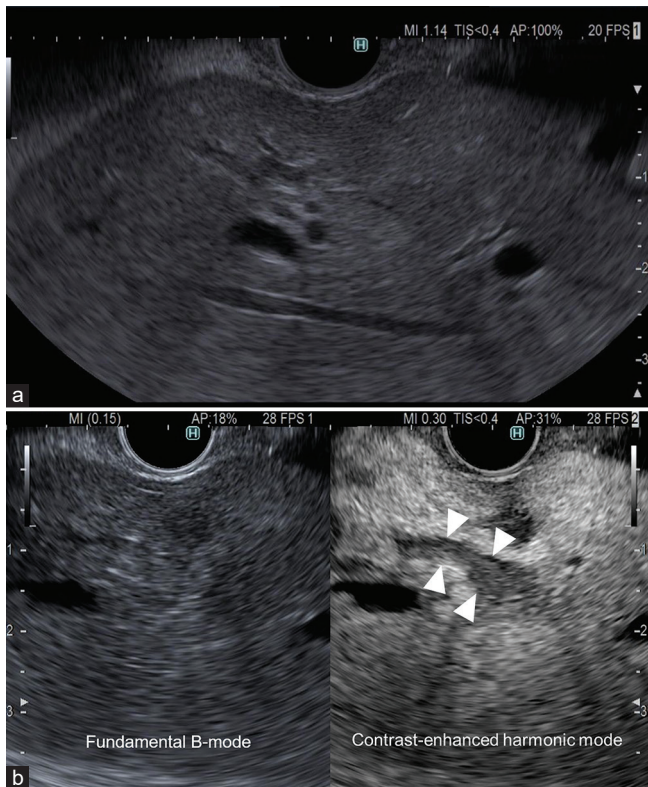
EUS-guided hepaticogastrostomy with contrast-enhanced harmonic imaging. (a) Fundamental B-mode EUS imaging showing the left hepatic lobe. The dilated intrahepatic bile duct was unclear. (b) Contrast-enhanced harmonic EUS after a bolus injection of ultrasound contrast agent, showing enhancement of the liver parenchyma, but not of debris, as well as a clearly visible dilated intrahepatic bile duct
